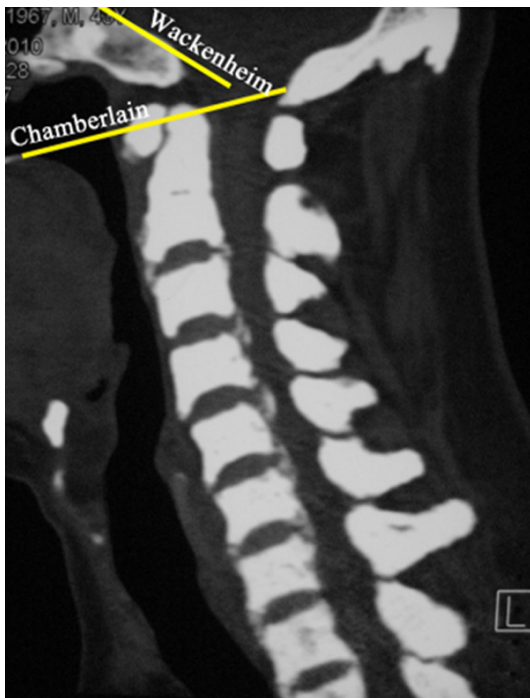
Sagittal CT scan image showing cervical canal stenosis with development of ossification of the posterior longitudinal ligament. Note the generalized increased density of the vertebrae.
